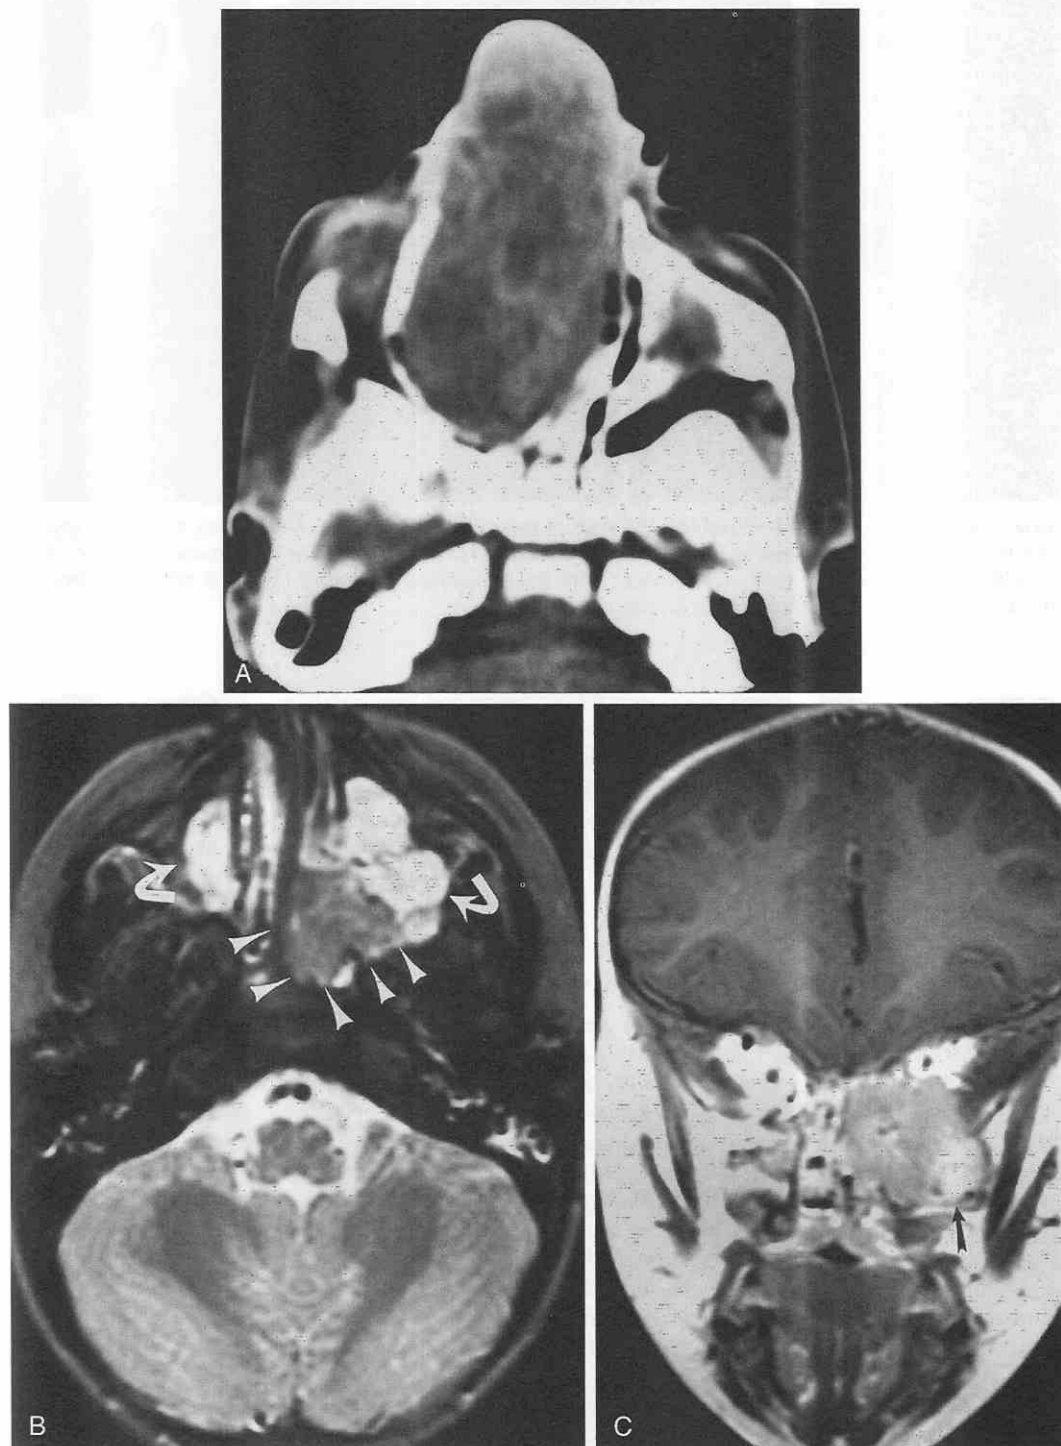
Nasopharyngeal teratoma. A, Axial noncontrast CT scan. A heterogeneous mass is filling and causing marked expansion of the nasal cavity in an infant. B, Axial T2-weighted MRI scan. A mass of the posterior nasal cavity (arrowheads) extends into the left maxillary sinus in another patient. The mass shows slightly heterogeneous signal, whereas maxillary sinus disease shows hyperintense signal (curved arrow). C, Coronal T1-weighted postcontrast MRI scan. Moderate enhancement of the mass is seen after contrast administration, with the obstructive maxillary sinus disease showing a greater degree of enhancement (arrow).
